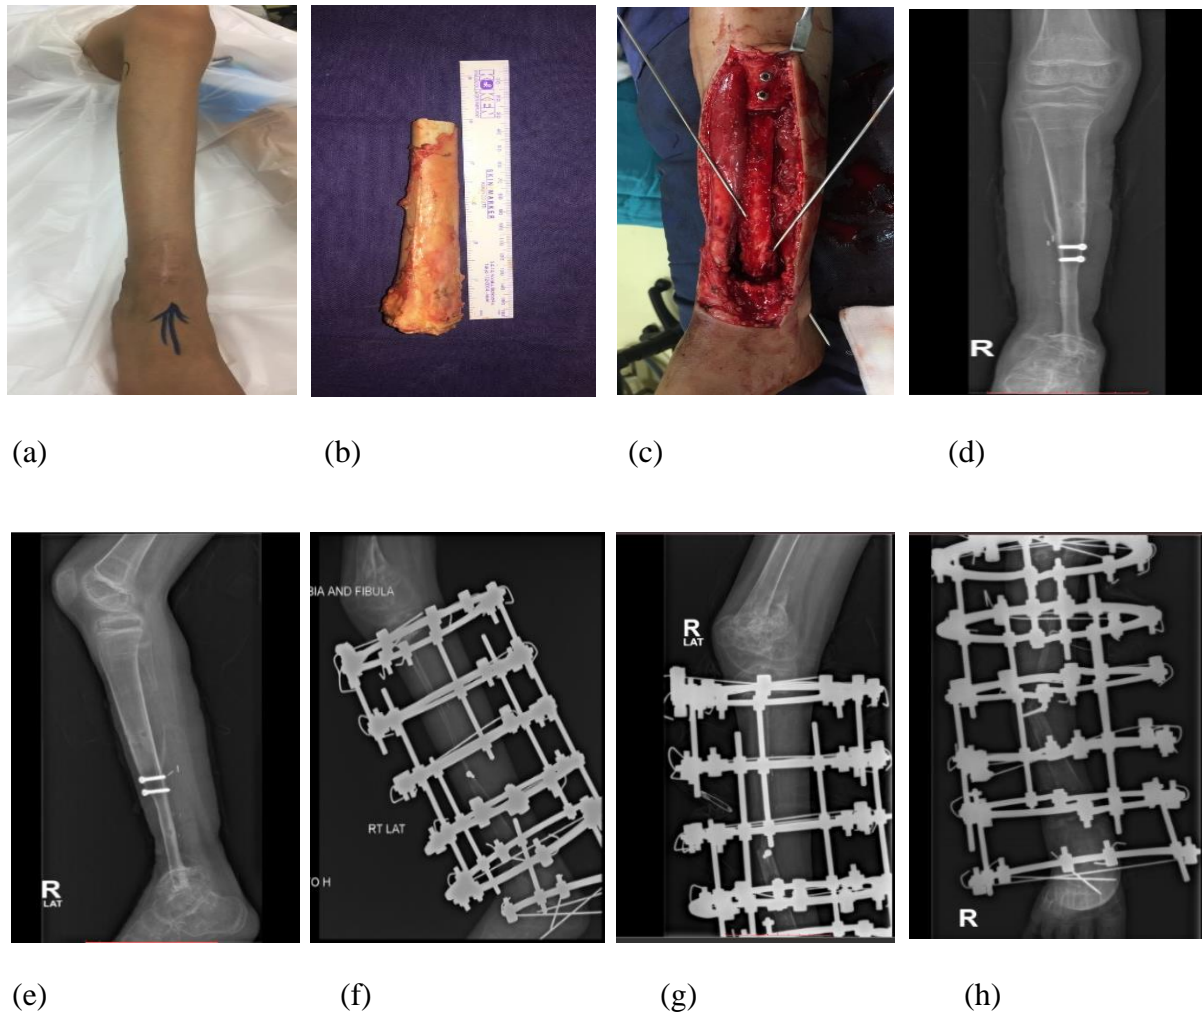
(a) 11 years old female with Ewing sarcoma of the right distal tibia (b) Gross picture of 12 cm excised tumor (c) Intraoperative image after fixation of the vascularized fibula as a single barrel with plates and screws (d) & (e) Anterior and Lateral view of X-ray left tibia after 2 months of reconstruction showing the union of bones (f), (g) & (h) Different X-ray views showing Ilizarov fixation after the fracturing of the fibula at 8 months postoperatively.
